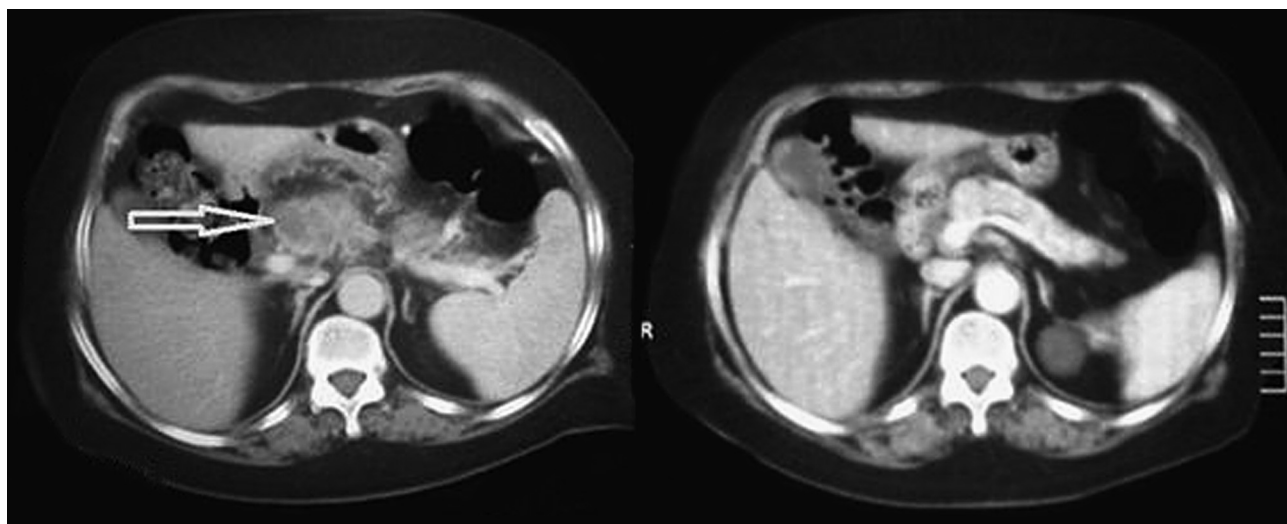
Cystic components in heterogeneous pancreas shown by CT prior to treatment (left) and normal appearance after treatment (right).
